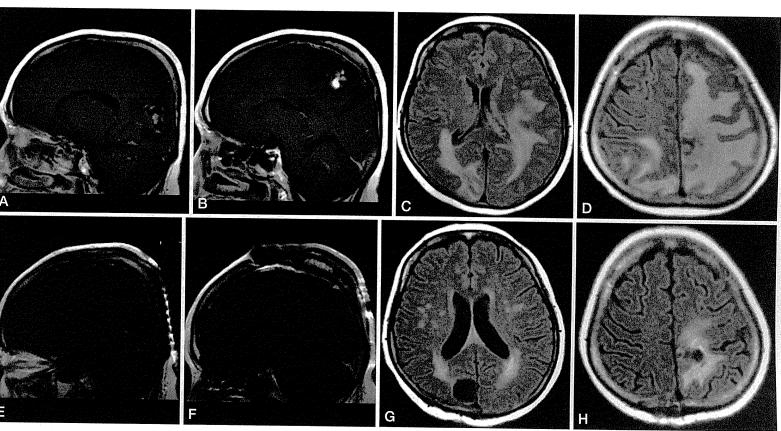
Typical MRI findings of radiation necrosis. This radiation necrosis was derived from metastatic brain tumors treated by stereotactic radiosurgery (SRS). A, B: Preoperative Gd-T1 MRI, C, D: Preoperative FLAIR MRI, E, F: Postoperative Gd-T1 MRI, G, H: Postoperative FLAIR MRI.
